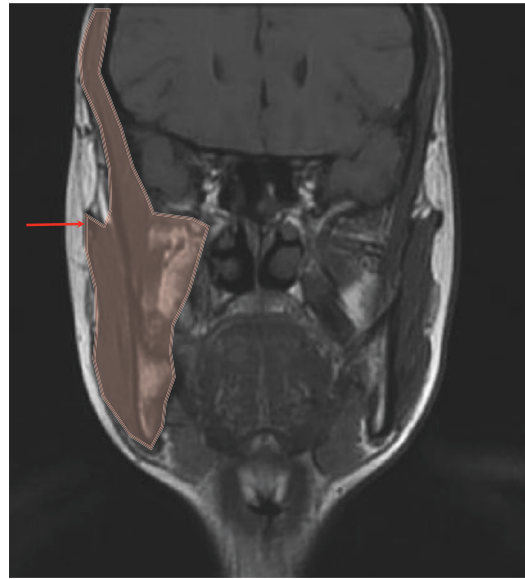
Coronal T1W MRI face/head. The red-shaded area indicates components of the right masticator space, divided into supra- and infrahyoid regions by the zygomatic arch (red arrow)
